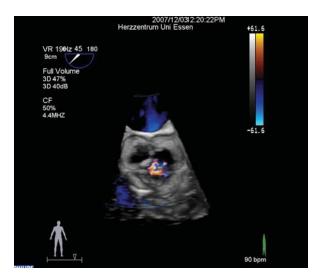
Transesophageal echocardiogram (3-dimensional view with color flow) shows the quadricuspid aortic valve.
